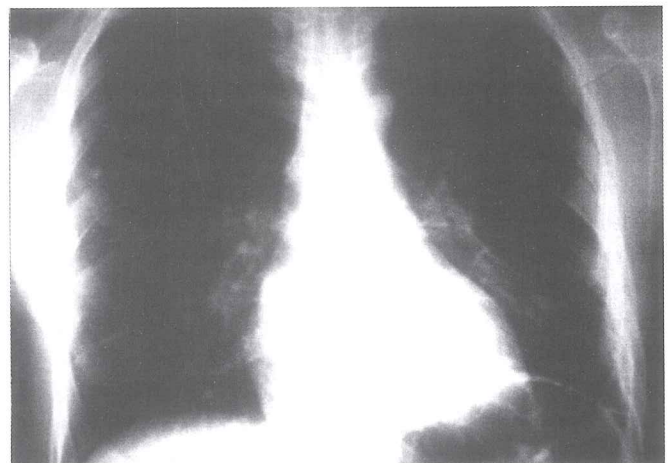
Control chest X-ray obtained 2 months after the second operation.
